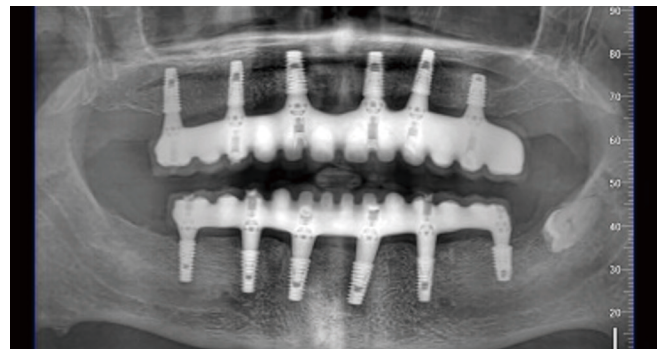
Post-op Radiography
